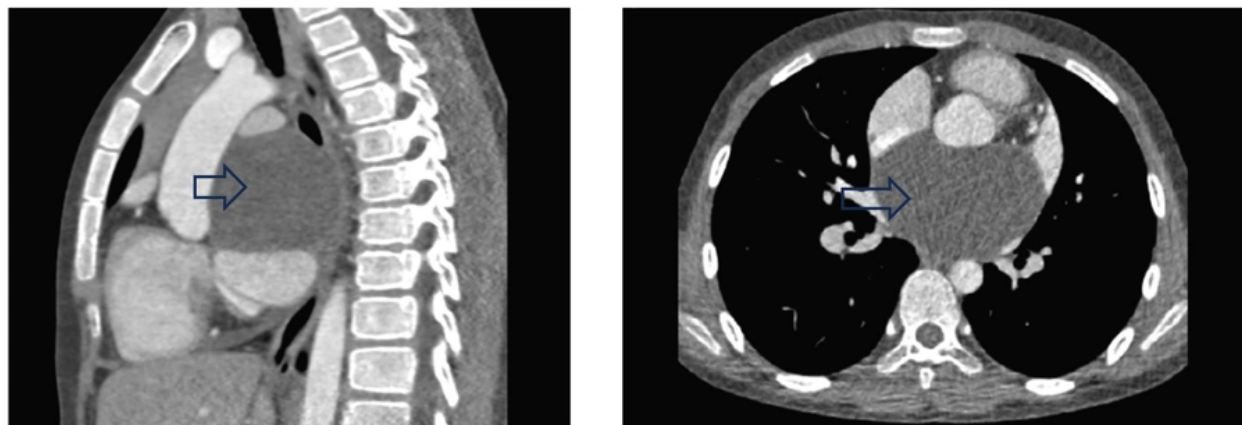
Pericardial cyst (PC) in cardiac computed tomography angiography (CTA)
